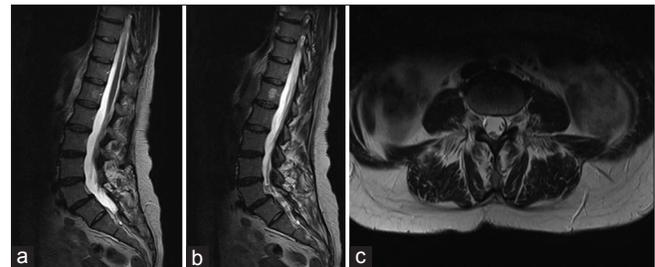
Control MRI scan, 5 years after initial tumor occurred, in sagittal (a and b) and transverse plane (c), revealed no recurrence of tumors
